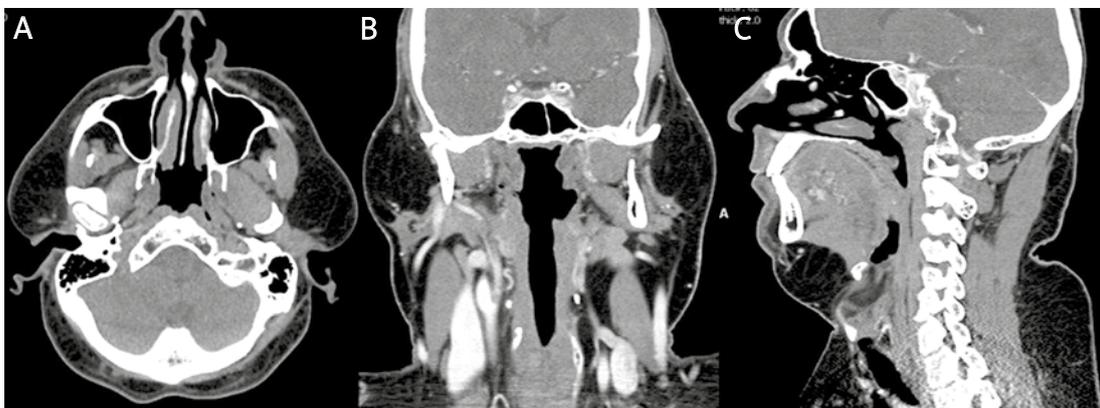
A-C. Head and neck CT showing the symmetrical enhancement of the lipomatous tissue
